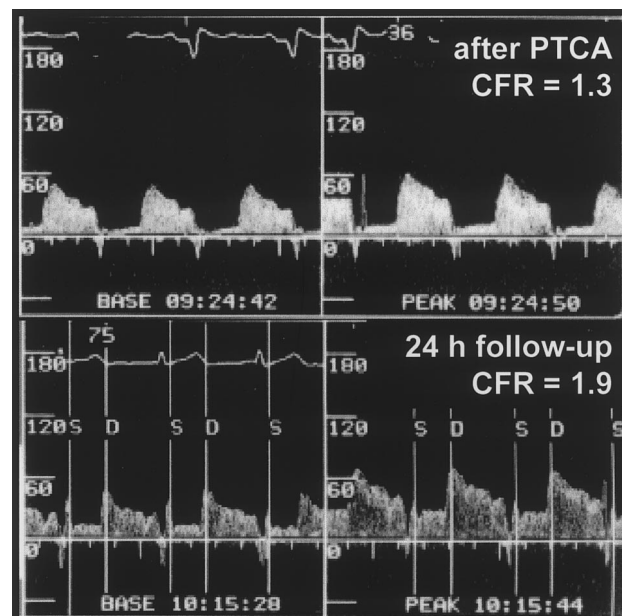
Doppler flow velocity tracings of patient with anterior AMI before and 24 hours after PTCA (same patient as in Figure 3). CFR in infarct-related artery increased from 1.3 immediately after revascularization (top) to 1.9 at 24-hour follow-up (bottom).
